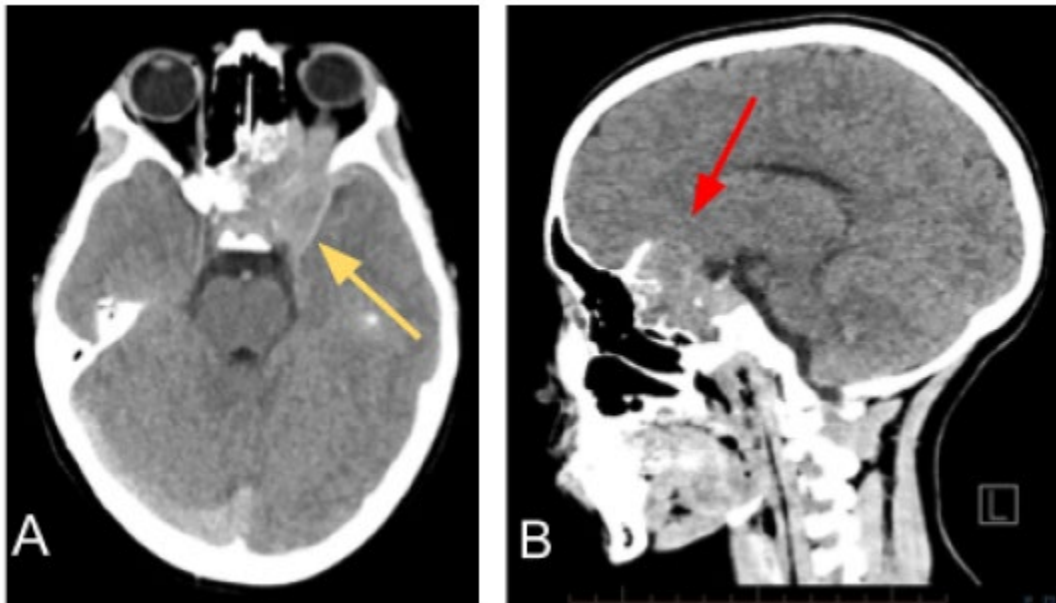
Non-contrast enhanced CT axial (A.) and sagittal (B.) planes demonstrating a mass (yellow arrow) centered in the left sphenoid extending into the superior and posterior left orbit. Additionally, there is cortical destruction (red arrow) and no evidence of internal mineralization.
